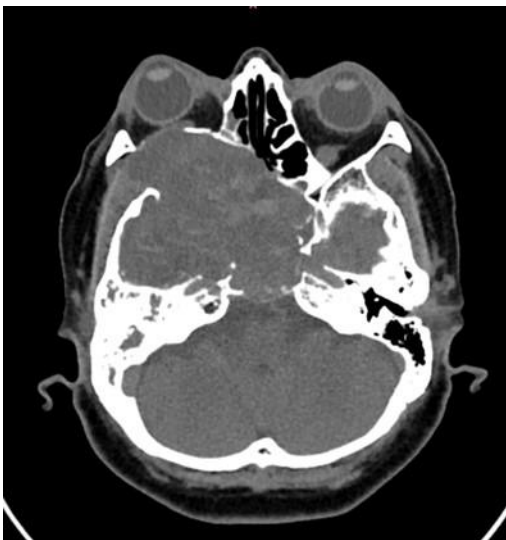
Superior cut on the CT brain showing the sinonasal mass extending to the orbital apex compression on the optic nerve region, eroding skull base and extends intracranially.
